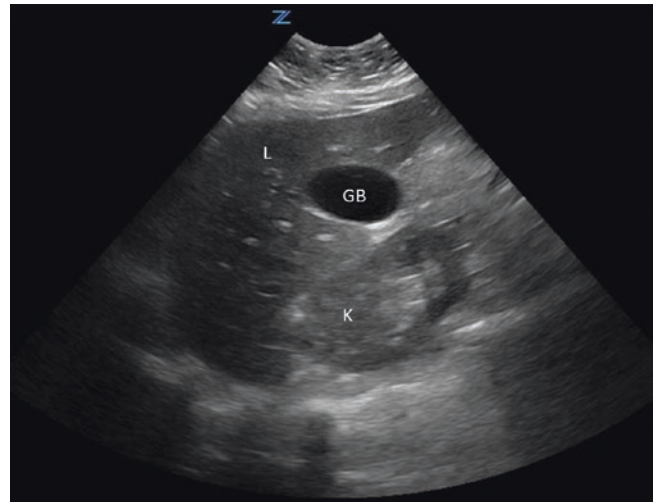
Ultrasound image of the gallbladder in the transverse plane. *GB* Gallbladder, *L* Liver, *K* kidney. Image courtesy of Huidong Kang
